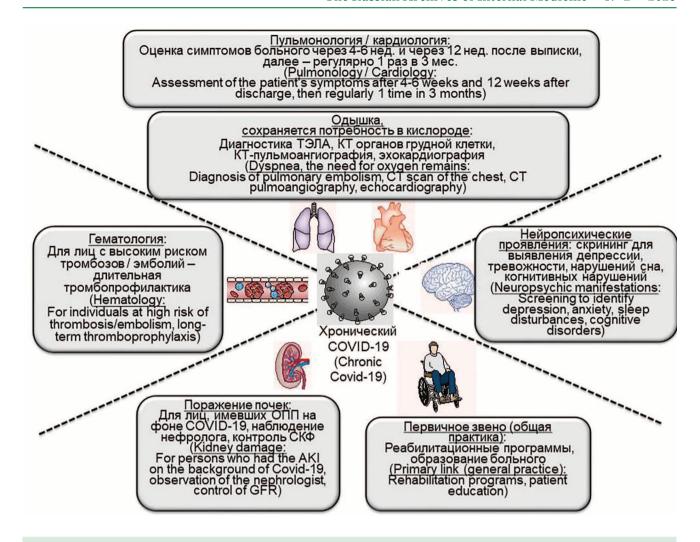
Multidisciplinary approach to the COVID-19 survivor (adapted from Nalbandian A. et al., 2021) Note: PE — pulmonary embolism; CT — computed tomography; AKI — acute kidney injury; GFR — glomerular filtration rate
